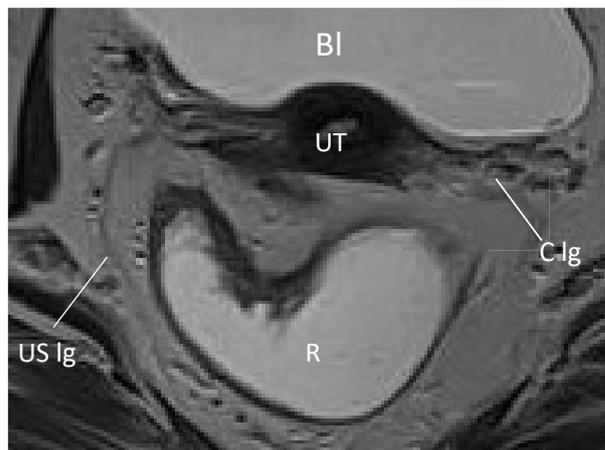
Axial T2_ weighted MR image showing the reticulo-troncular feature of the cardinal ligament as opposed to the thin, curvilinear appearance of the uterosacral ligament travelling toward the anterior aspect of sacral bone. BI= bladder; UT= uterus; R= rectum; US lg= uterosacral ligament.
